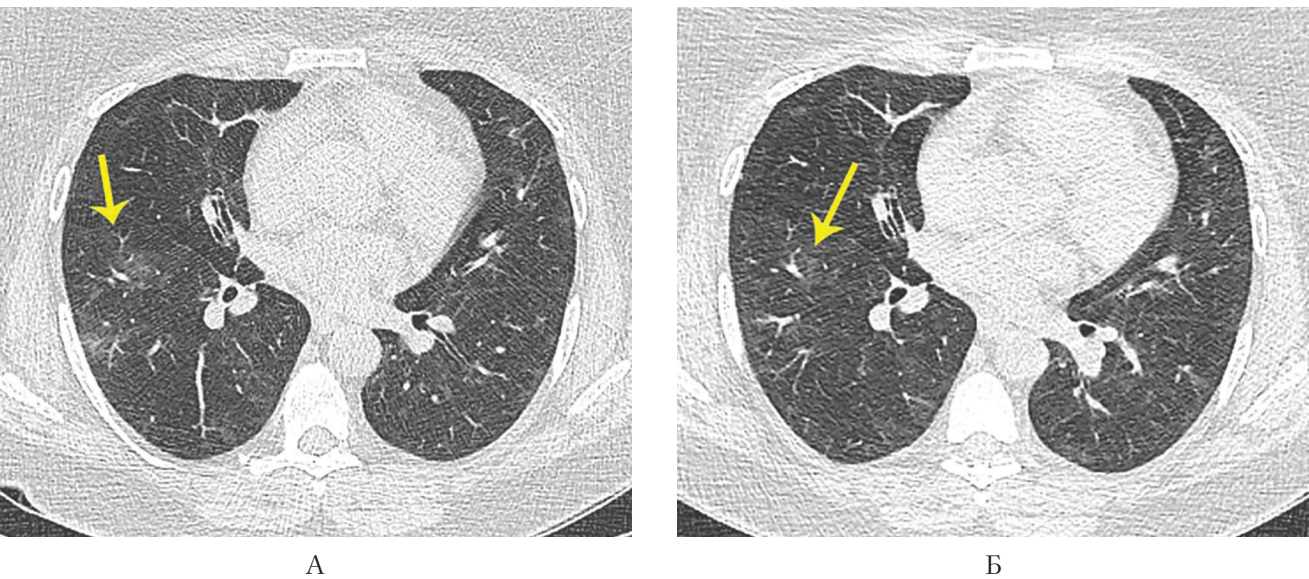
Ame patient, 3 weeks after discharge. Re-hospitalized with residual symptoms and ground glass opacities at CT scan
